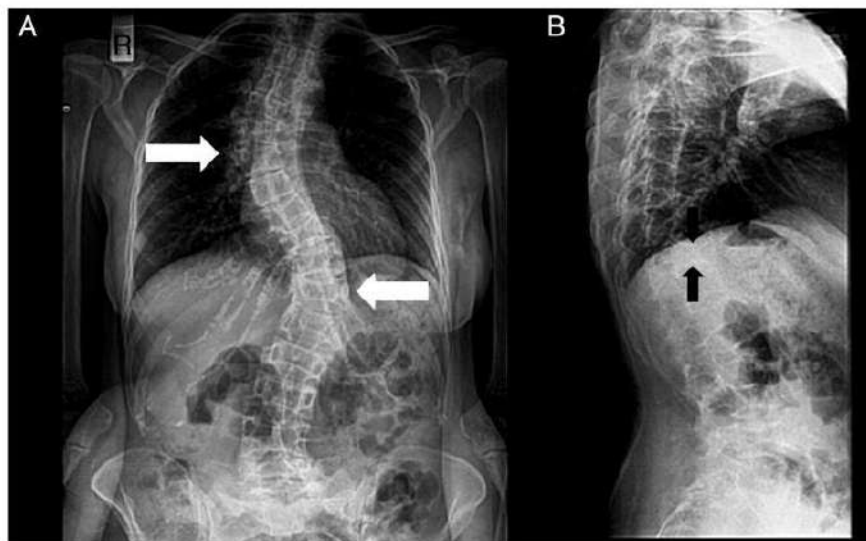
Radiographs of a patient’s spine. (A) Anteroposterior view. (B) Lateral view. The following are noted: scoliosis (double major—with a right thoracic and a left thoracolumbar curve—white arrows), and biconcave deformities of the upper and lower endplate (fishbone deformity—black arrows) of many vertebrae and decreased bone density.
